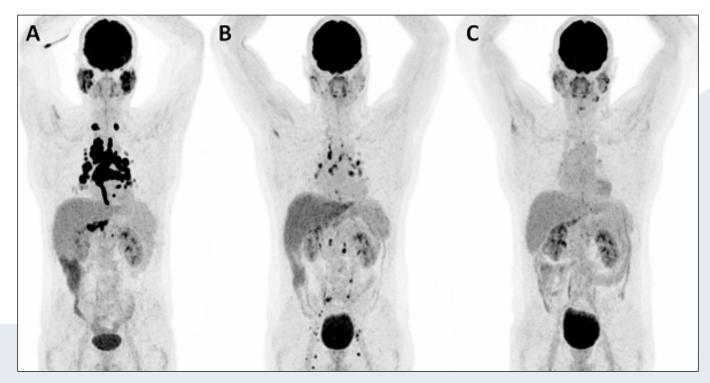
Anterior ¹⁸F-FDG PET maximum intensity projection, showing pathological uptake in parotid salivary glands and lymph nodes in supraclavicular, mediastinal, lung hilum and retroperitoneal stations (A). Follow-up after one year, showing normalised uptake in the parotid salivary glands and significant decrease in uptake in the lymph nodes (B). Follow-up after two years, showing a relapsed uptake in the parotid salivary glands (C).
